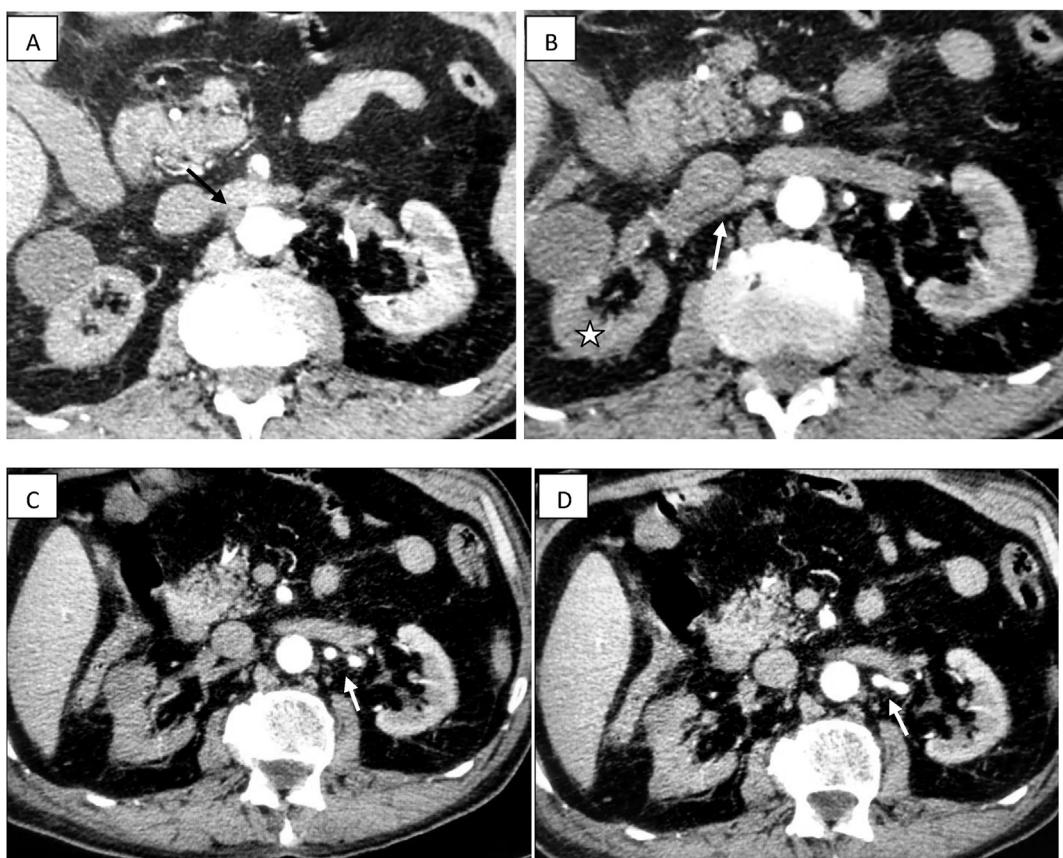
Abdominal CT angiography images in the axial plane show: A. a filling defect in the emergence of right renal artery (arrow), B. a non opacified right renal artery (arrow) and non enhanced right kidney (star), C. and D. Left renal artery well opacified (arrow).
